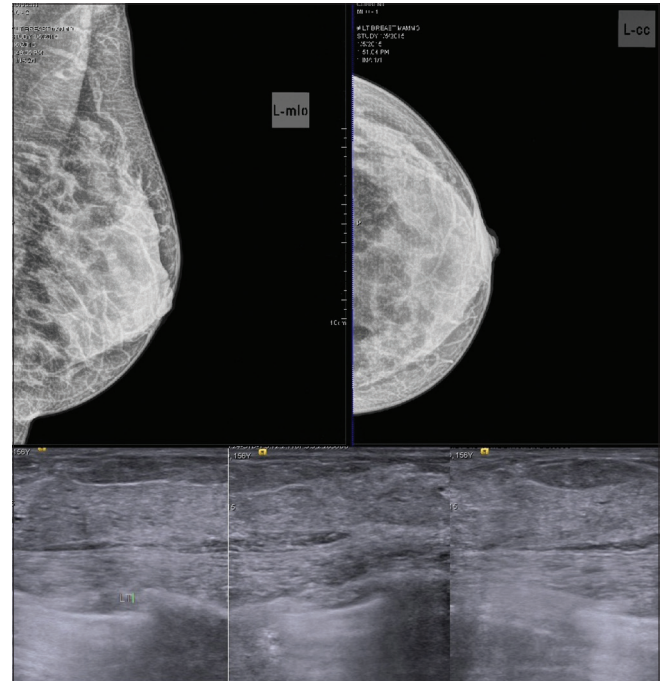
Normal dense breast parenchyma and ultrasound images
